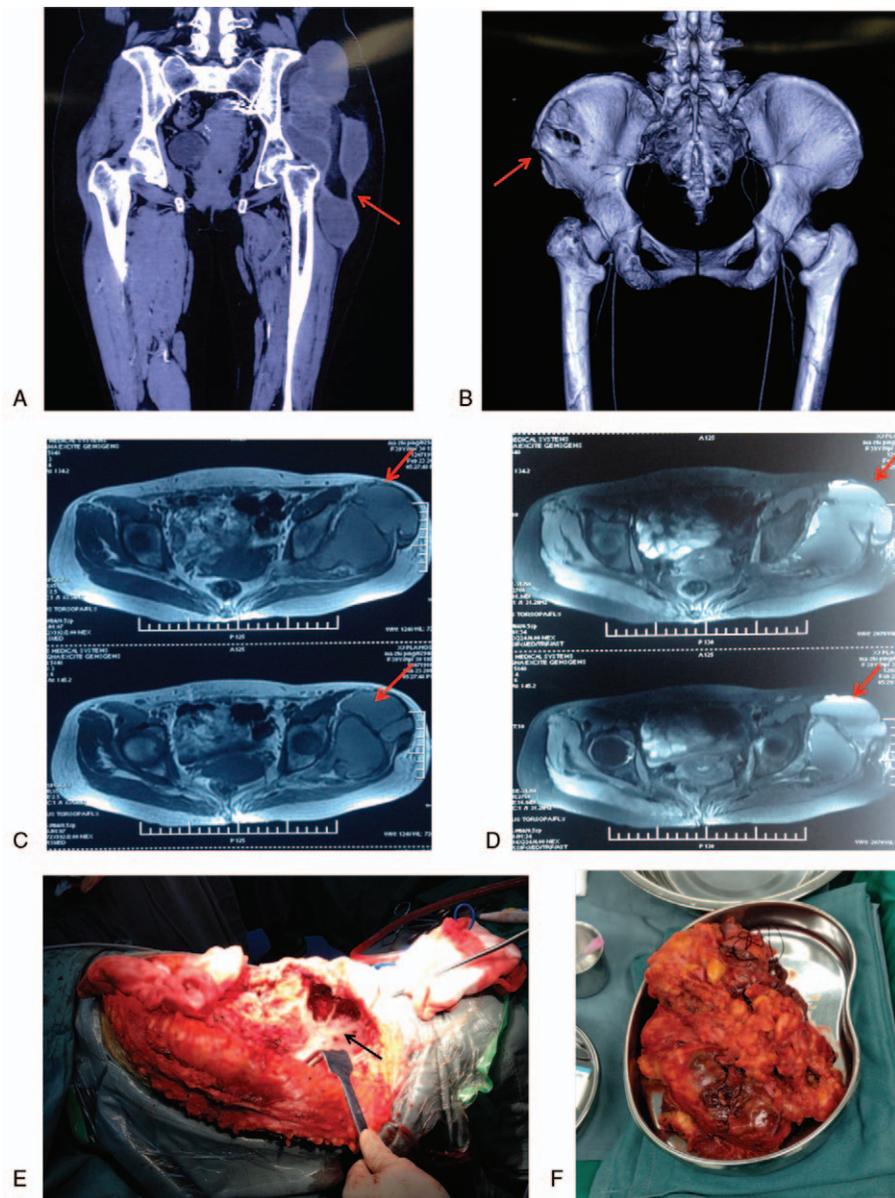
A–D, X-ray, 3-D CT, and MRI of the left hip showing a mass with division and bone destruction in a 39-year-old female patient. E, Photographs of the intraoperative situs. F, Photographs of the resected malignant triton tumor with partial iliac bone. CT=chemotherapy, MRI=magnetic resonance imaging.
